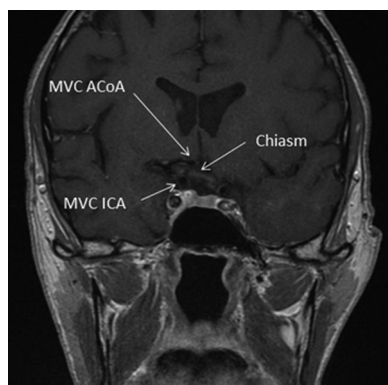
Preoperative magnetic resonance imaging showing the sandwiched right optic nerve/chiasm. AcoA, anterior communicating artery; ICA, internal carotid artery; MVC, microvascular compression.
